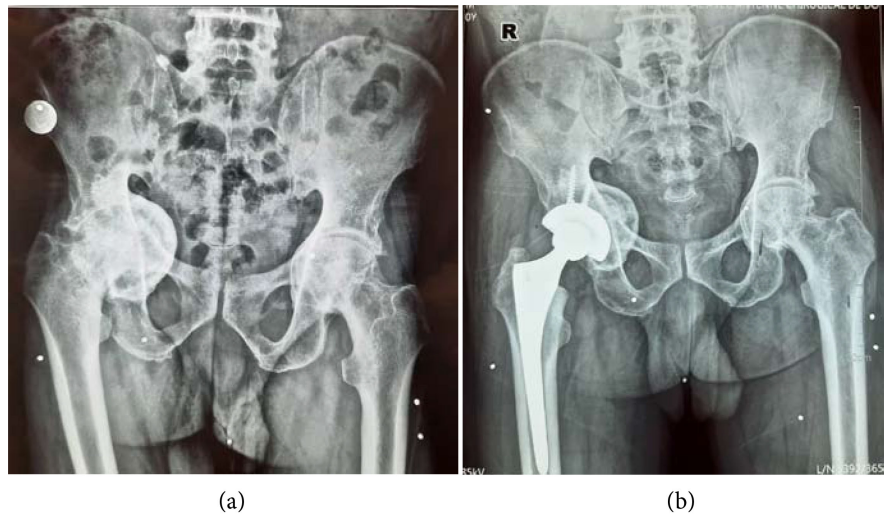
((a) (b) Left coxarthrosis on dysplastic hip; (c) Intraoperative image showing the acetabuloplasty made from a graft taken from the femoral head, screwed and milled with the acetabulum; (d) Postoperative control radiograph.
